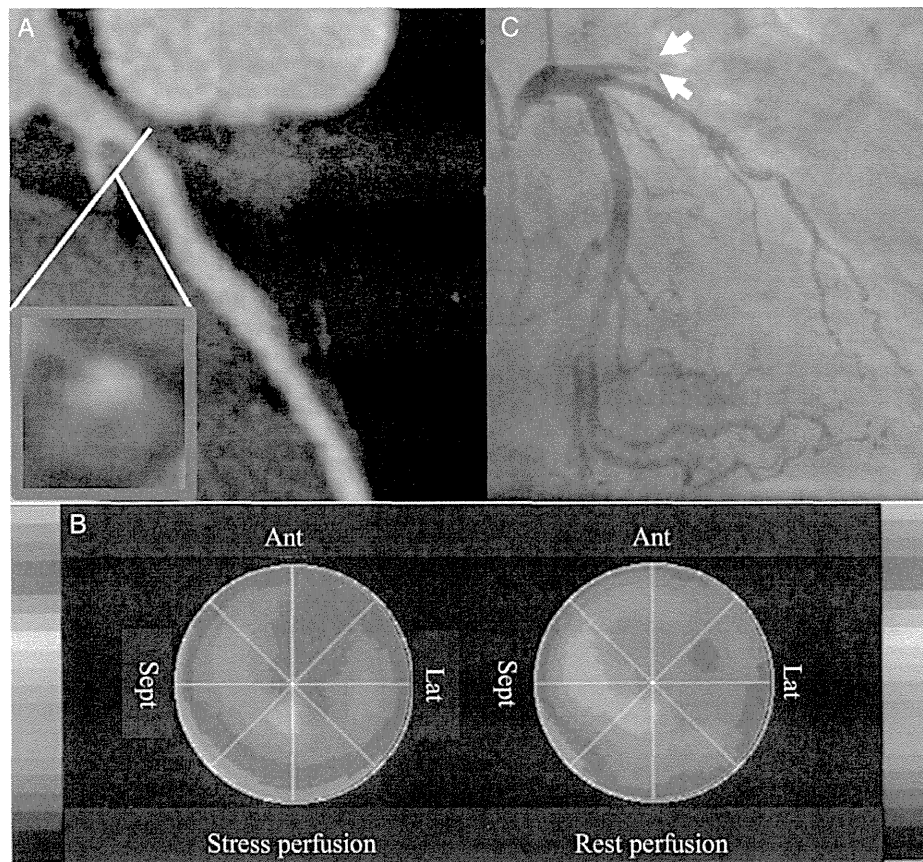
A representative case of CTCA with a vulnerable featured plaque and normal perfusion imaging on SPECT and subsequent ACS events. (A) CTCA image shows an atherosclerotic plaque with high-risk signs of PR, low-attenuation, and ring-like sign at the proximal LAD. (B) Stress-rest SPECT perfusion polar maps show normal perfusion. (C) One-year later, acute myocardial infarction occurred at the high-risk plaque. Invasive coronary angiography showed the total occlusion of LAD artery (arrows). ACS, acute coronary syndrome; CTCA, computed tomographic coronary angiography; LAD, left anterior descending artery; SPECT, single-photon emission computed tomography.
